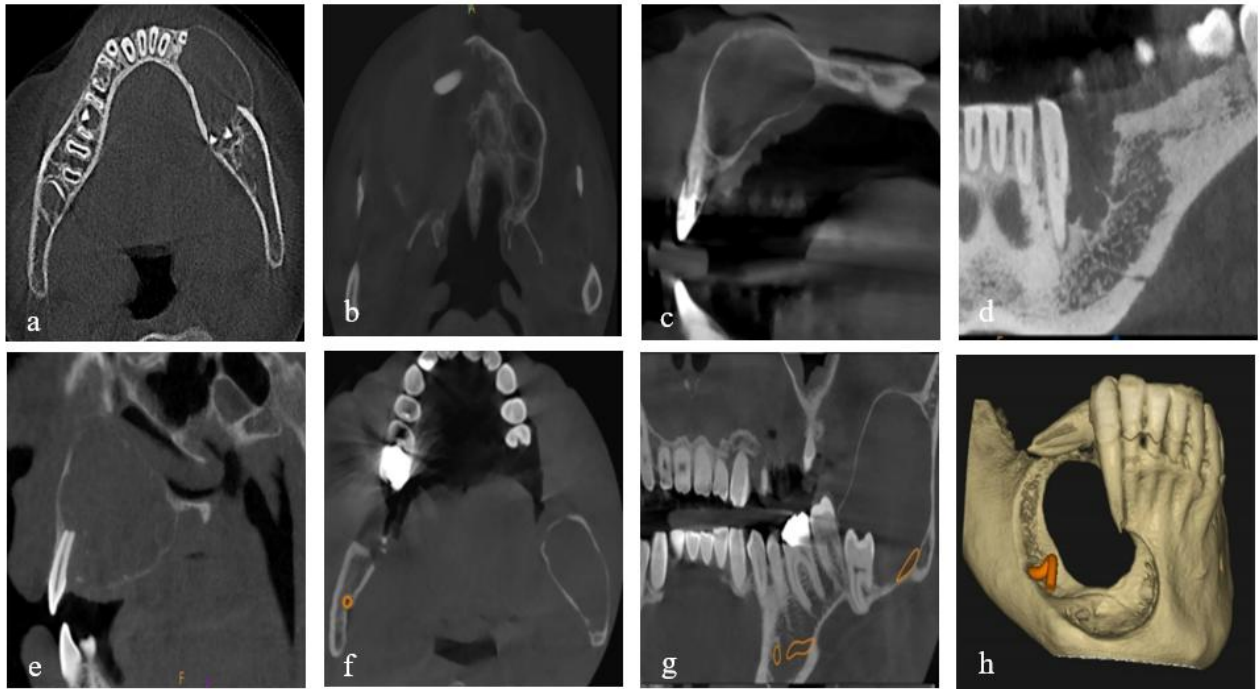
CBCT images depicting distinct jaw lesions with different characterization: (a) axial sections of a dentigerous cyst with well-defined borders, and (b) axial section of adenoid cystic carcinoma showing ill-defined margins. (c) sagittal views of a radicular cyst presenting a unilocular radiographic pattern; (d) coronal views of ameloblastoma exhibiting a characteristic multilocular appearance. (e) Demonstrates a sagittal view revealing apical root resorption associated with a radicular cyst. (f) axial and (g) coronal views with buccolingual expansion in a dentigerous cyst. Furthermore, image (h) shows a three-dimensional view of cortical perforation in fibromyxoma.
